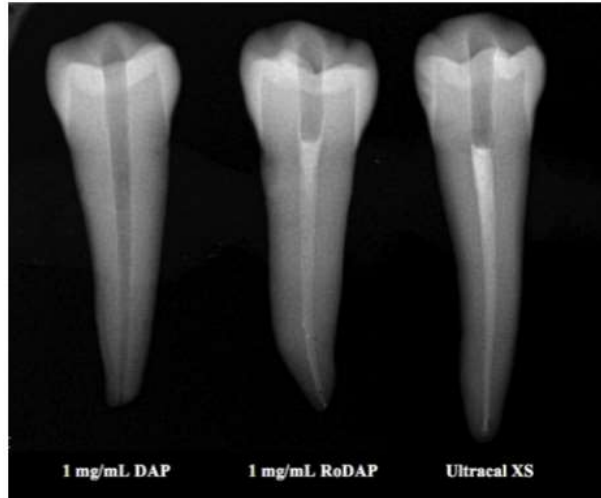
Radiograph demonstrating similar radiopacity of 1.0-mg/mL RoDAP compared with Ultracal XS when 30% w/v zirconium oxide was added to DAP as a radiopacifying agent.
